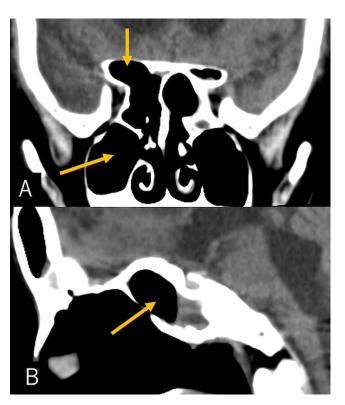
Noncontrast coronal (A) and midsagittal (B) computed tomography performed at the completion of antibiotic therapy showing resolution of the sinusitis (arrow).
